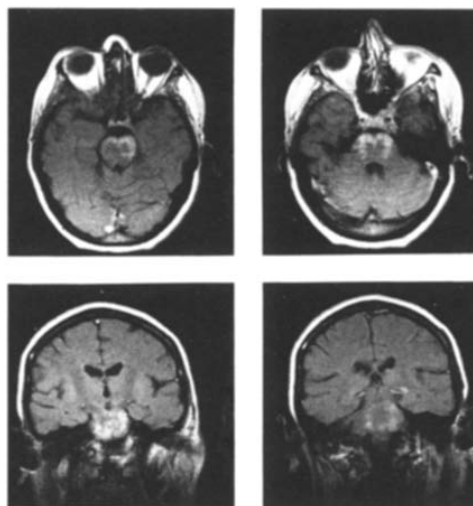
Gadolinium-enhanced MRI of patient no. 12, showing increased signal intensity in the pons and midbrain.
